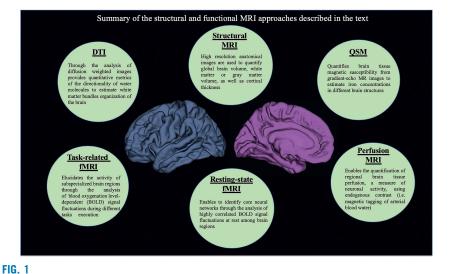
summarizes the main morphological and functional MRI potentialities to apply to sex differences research.
